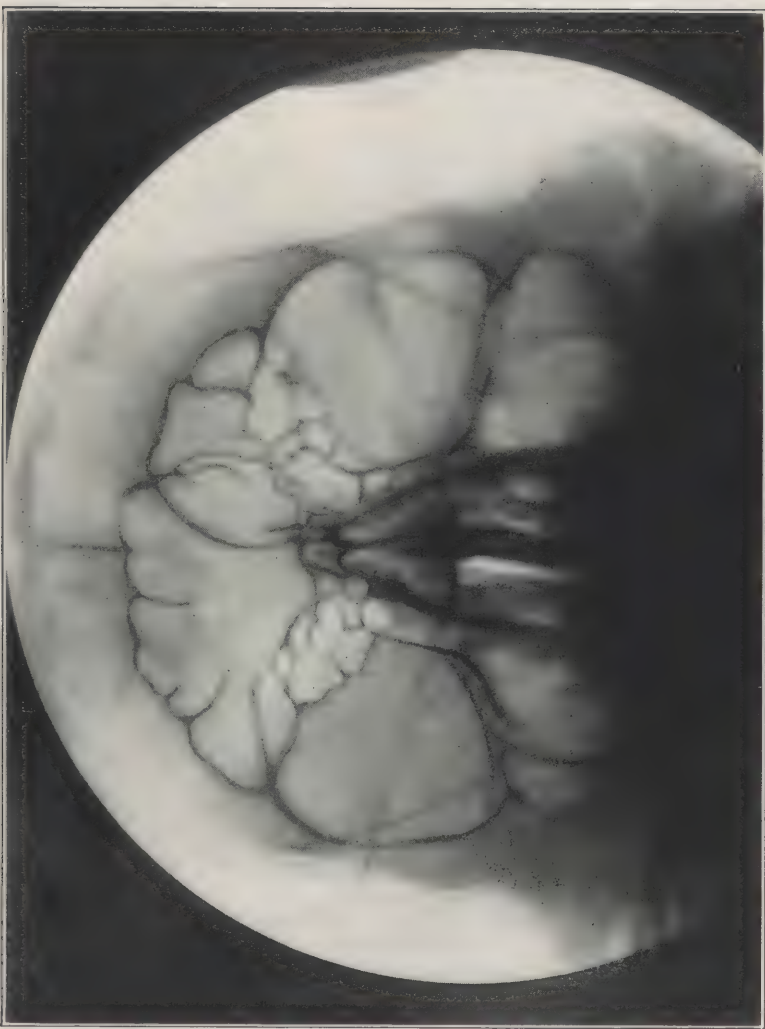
This X-ray plate clearly shows the very large frontal sinuses, with partial partitions and ridges running from the periphery. The partition between the sinuses starts from the center but deviates to the left. There are a great many small orbito-frontal cells extending from the ethmoidal capsules.
